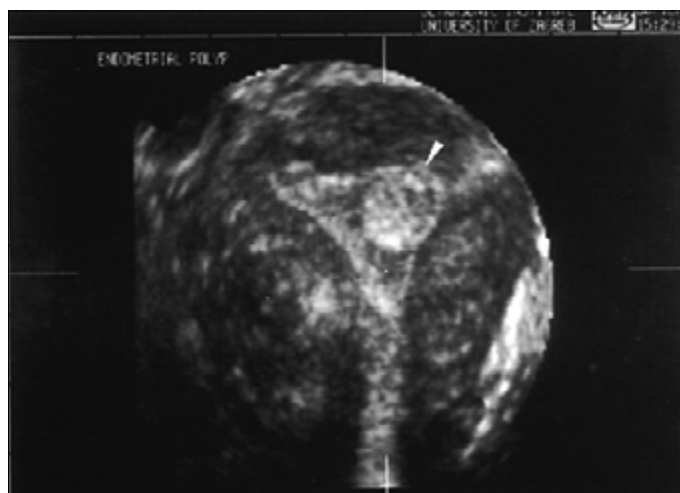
An endometrial polyp diagnosed by 3D ultrasound
